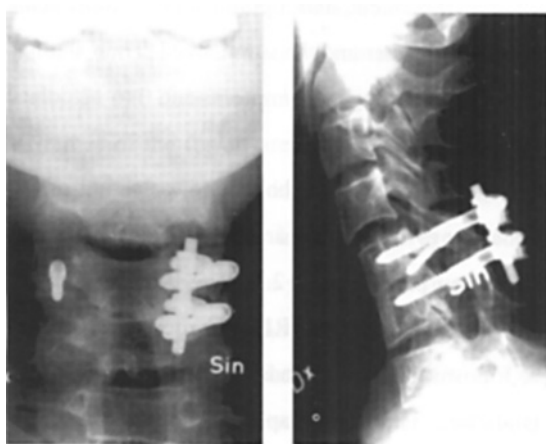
Example of a short construct. This 39 year old man (patient #21) suffered from posttraumatic kyphosis at C5-C6. The treatment consisted of anterior release, posterior release, reduction, and fixation with transpedicular fixation on one side and a single transarticular screw on the other, followed by anterior bone grafting. The one year follow-up radiographs revealed solid fusion.
